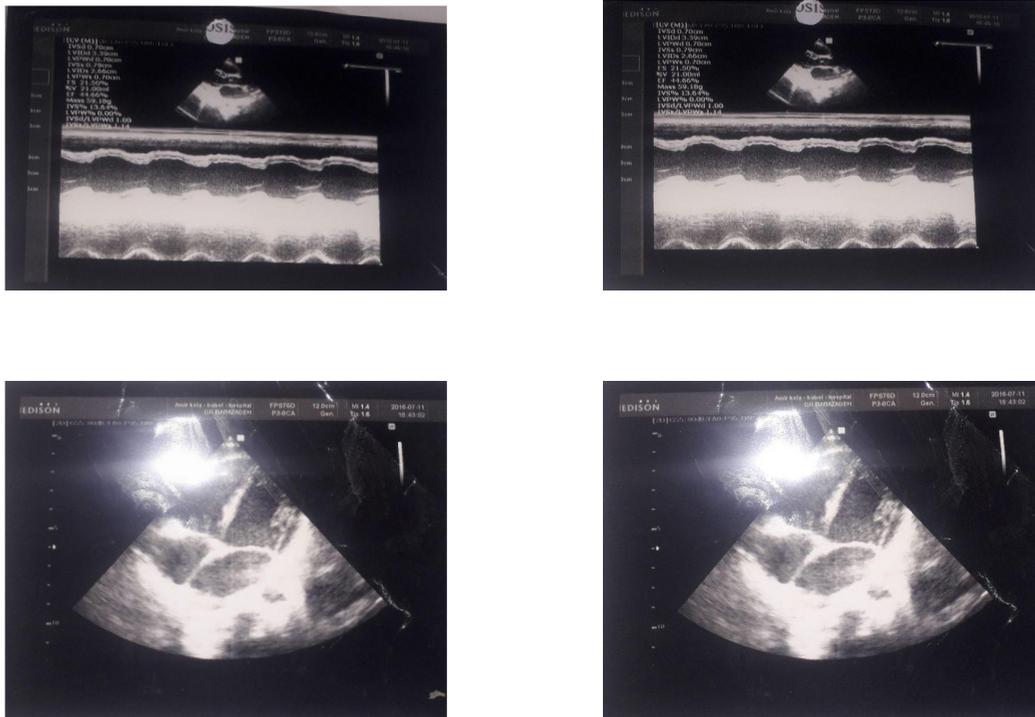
Echocardiography of case MMSDH
